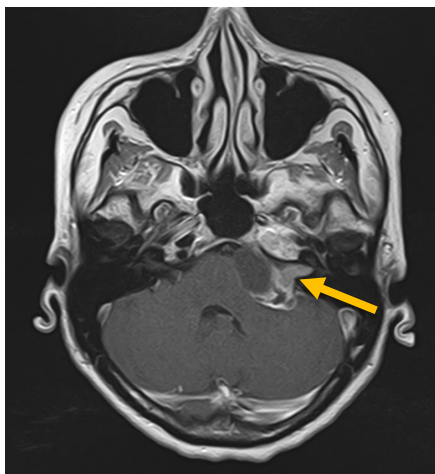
An axial T1-weighted magnetic resonance imaging scan with contrast administration, showing a vestibular schwannoma in the left cerebellopontine angle (arrow).
